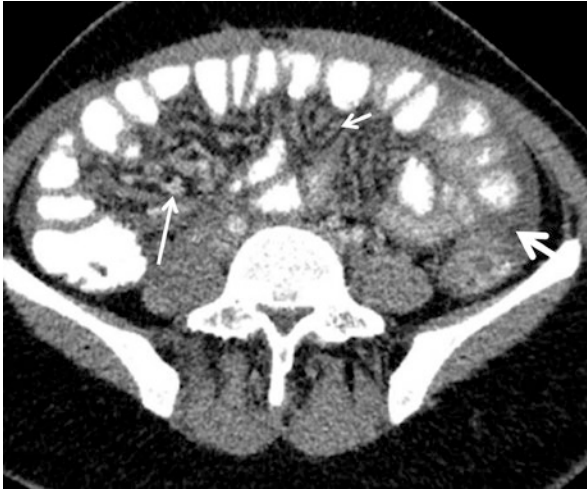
Omental changes in peritoneal tuberculosis on ultrasound (a–c) and CT (d–e). (a) Trilaminar pattern (thick Central hyperechoic layer surrounded by peripheral thin hypoechoic layers, cursors) of omental thickening (most common pattern). (b) Heterogenous pattern of omental thickening (cursors). (c) Monolayer hyperechoic pattern of omental thickening (cursors). (d) Axial contrast-enhanced CT shows smudged pattern of omental thickening (short arrow) with ascites (arrow). (e) axial contrast-enhanced CT scan shows smudged pattern of omental thickening (arrow) with omental micronodules (short arrow). Smudged pattern of omental thickening on CT is the most common pattern observed in peritoneal tuberculosis
